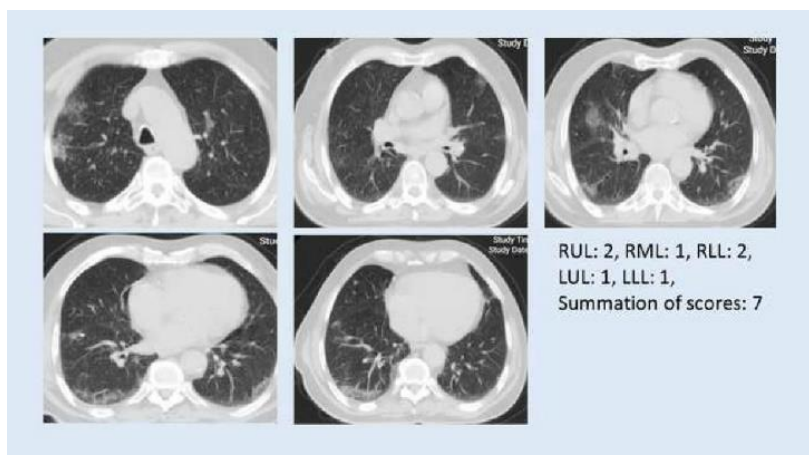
Axial CT images of a patient at several planes. The summation of scores was equal
